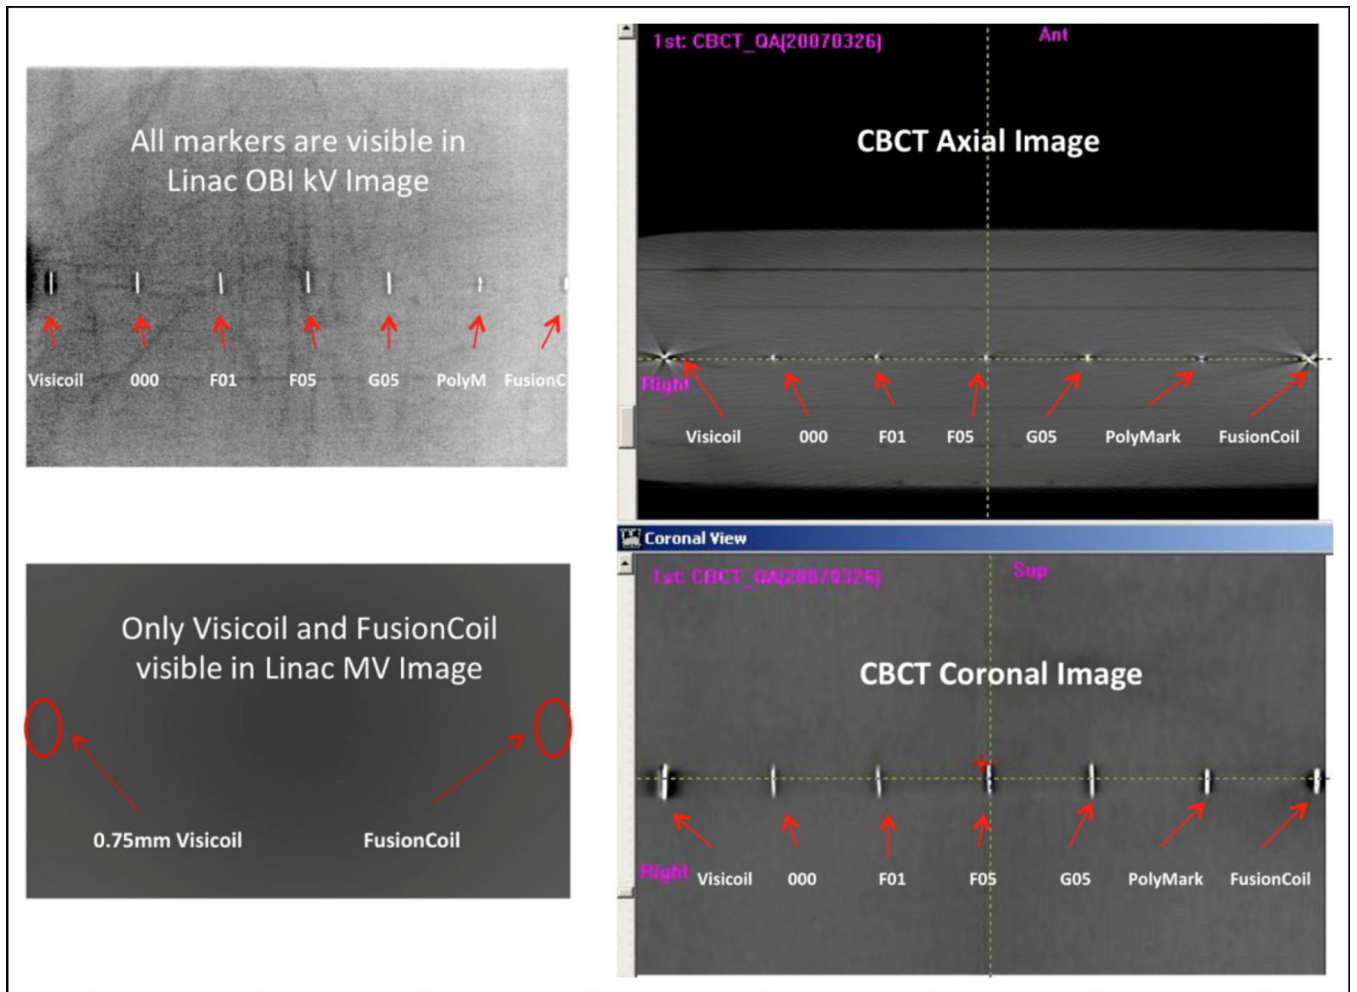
Linear accelerator (Linac)-based kilovoltage (kV), cone-beam computed tomography (CBCT), and megavoltage (MV) images.
